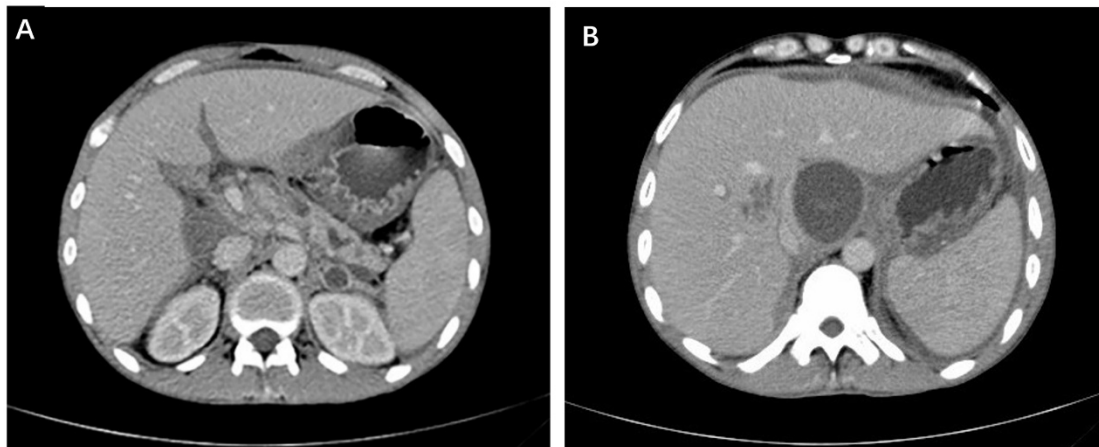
CT scan showed inflammation changes of the pancreas and peripancreatic tissue(A), pseudocyst formation(B)
